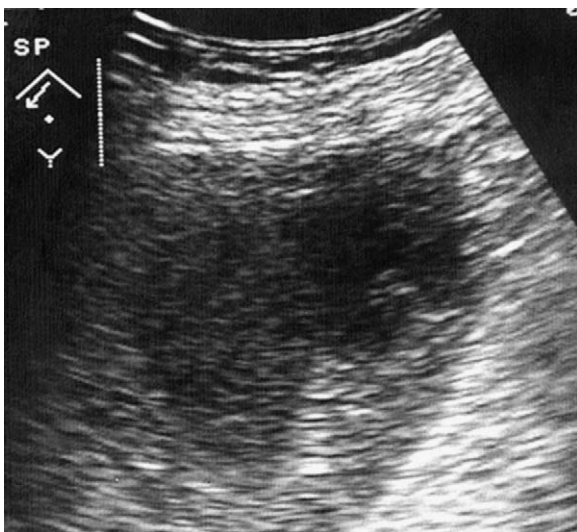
Bacterial abscess. The ultrasound scan shows a hypoechoic, ill-defined bilobate lesion in the lower third of the spleen.
